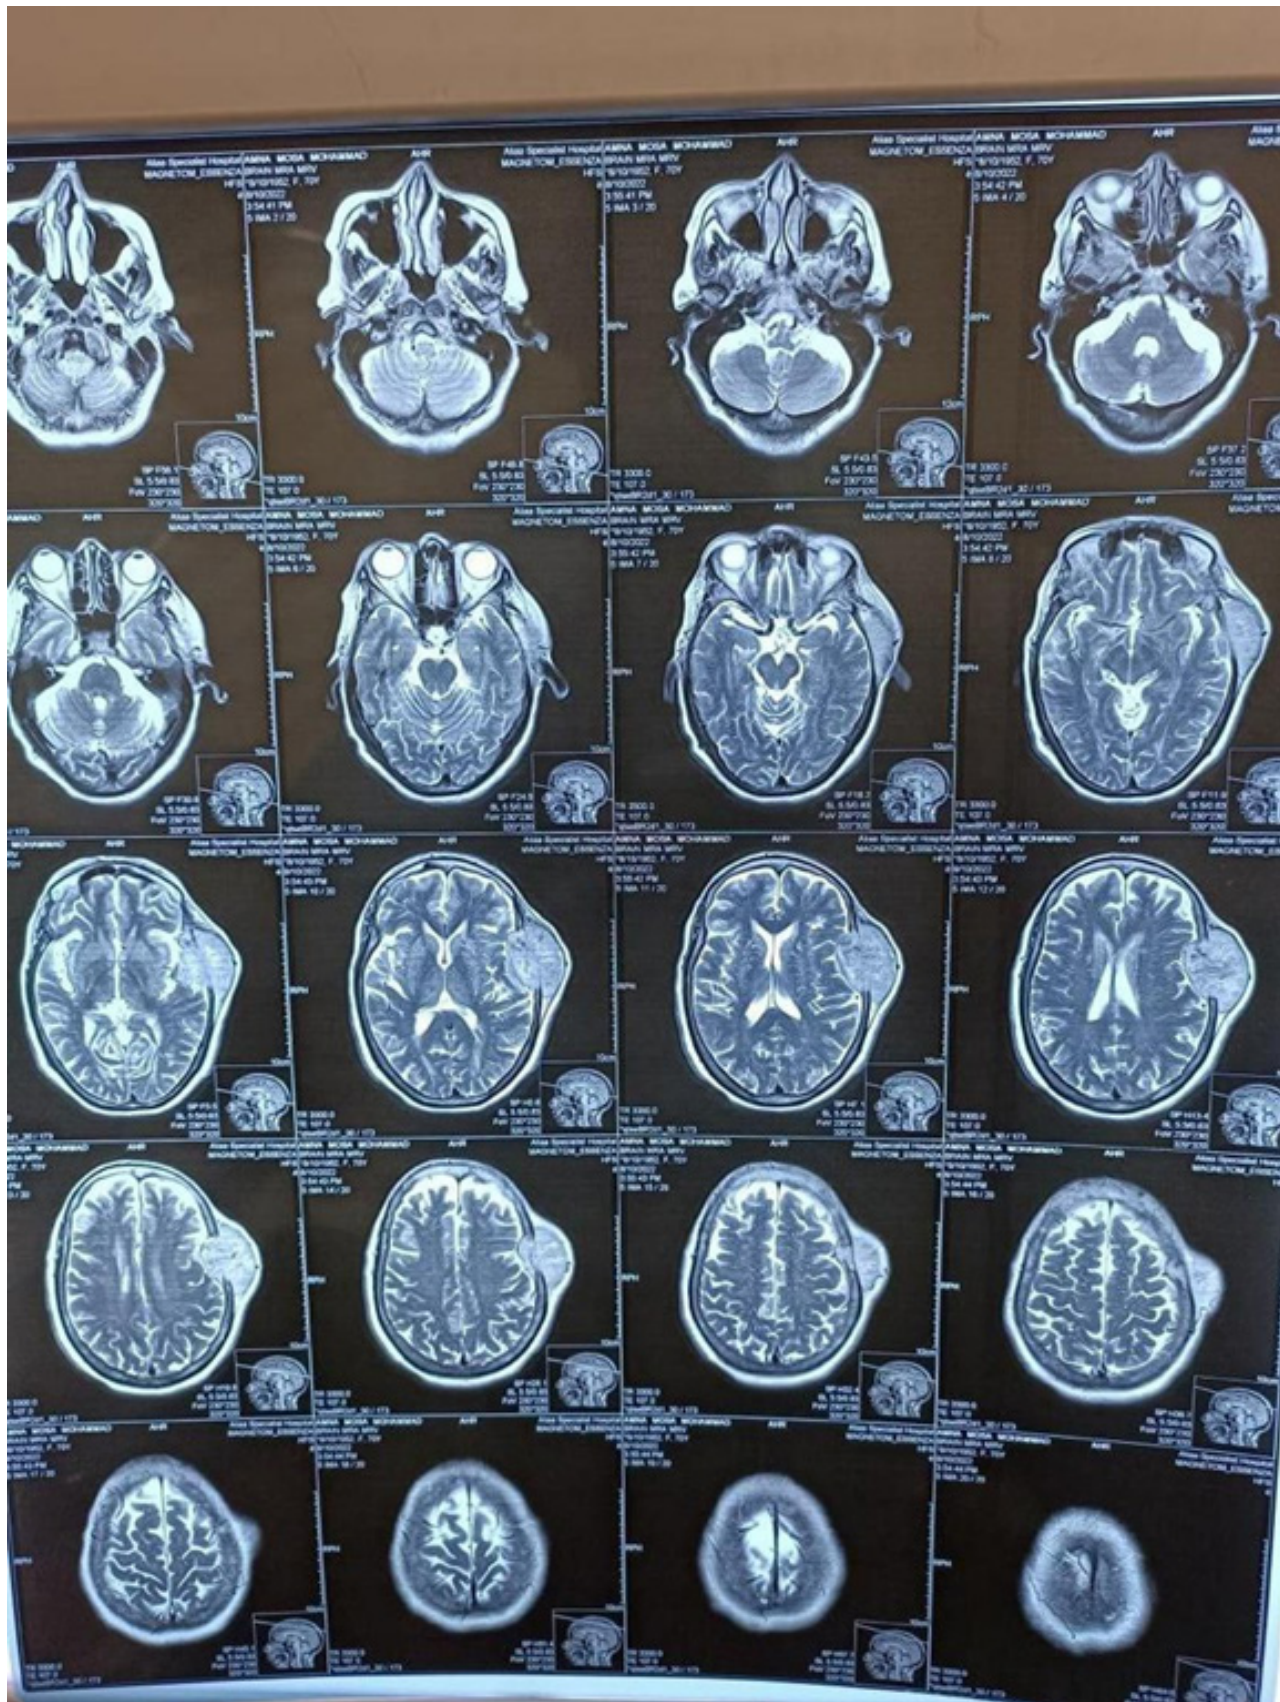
MRI scan with contrast, axial cut, T2 sequence shows hyper intensity of the lesion.
